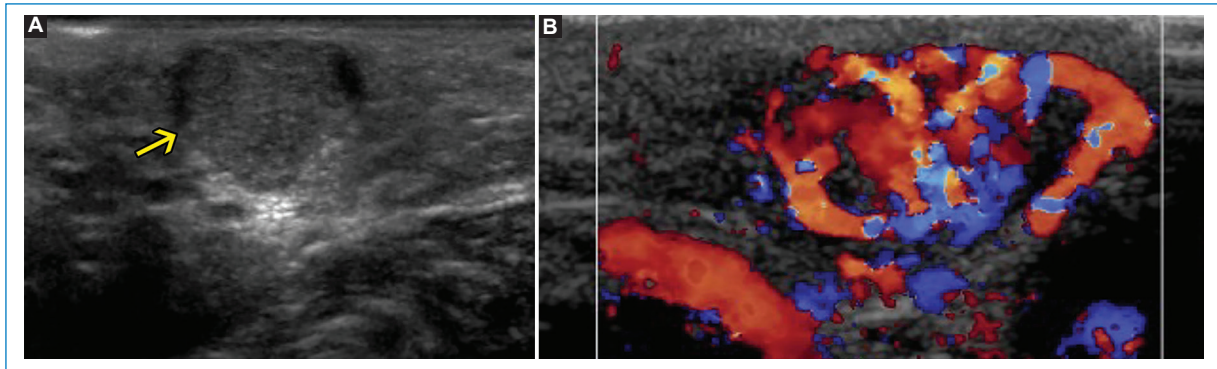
In this patient, a hypoechoic nodule (A) with a solid appearance, well delimited, is observed. With color Doppler (B) it shows multiple vascular structures (there is no soft tissue hypertrophy, unlike arteriovenous malformations).
